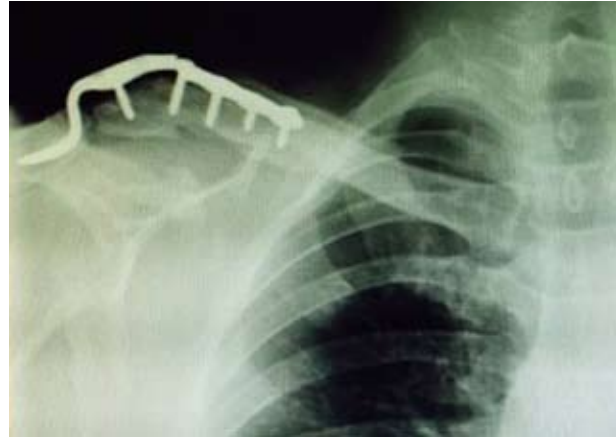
A radiograph after conservative treatment showing union of both distal clavicle fracture and clavicle fracture at medial end of the hook plate. The failure of implant hook plate was observed.
